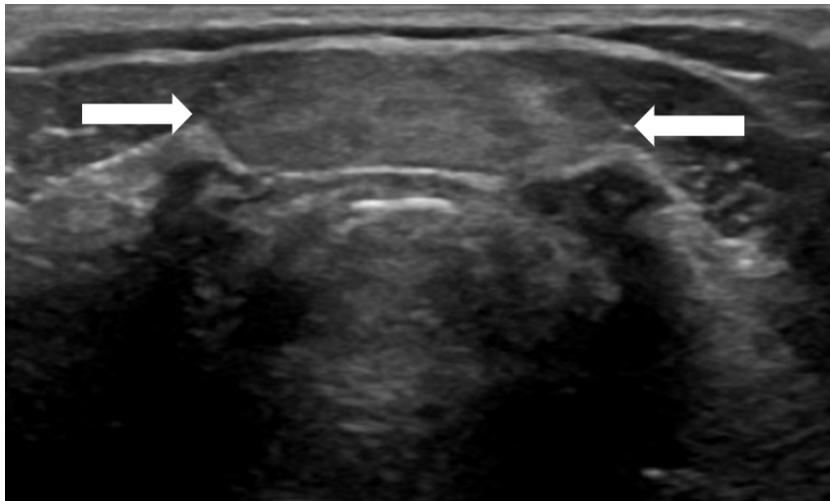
Gri-skala ultrasonografi incelemesinde boyun orta hattta hyoid kemik düzeyinde izlenen posteriorunda akustik güçlenme oluşturan tiroglossal kanal kisti ile uyumlu lezyon (siyah ok).
